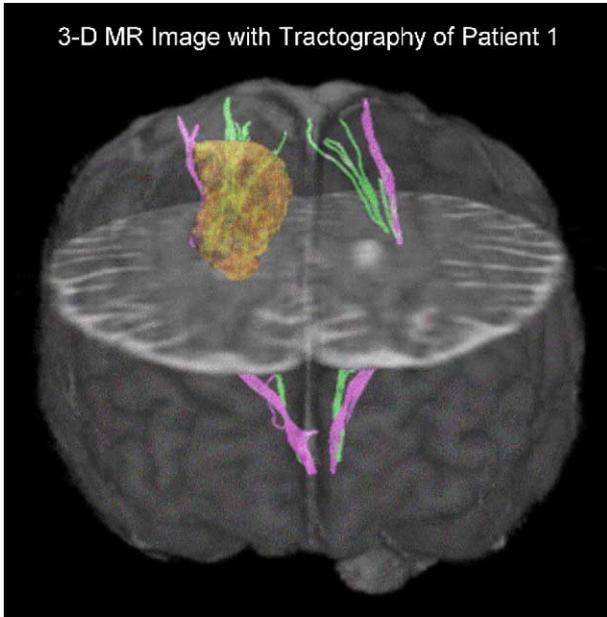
(Patient 1) Three-dimensional reconstruction of the MR image with tractography. The tumor involving the right frontal lobe is colored in orange, the pyramidal (corticospinal) tract in purple, and the sensory tract in green. The tumor posteriorly compresses both the pyramidal and sensory tract.
